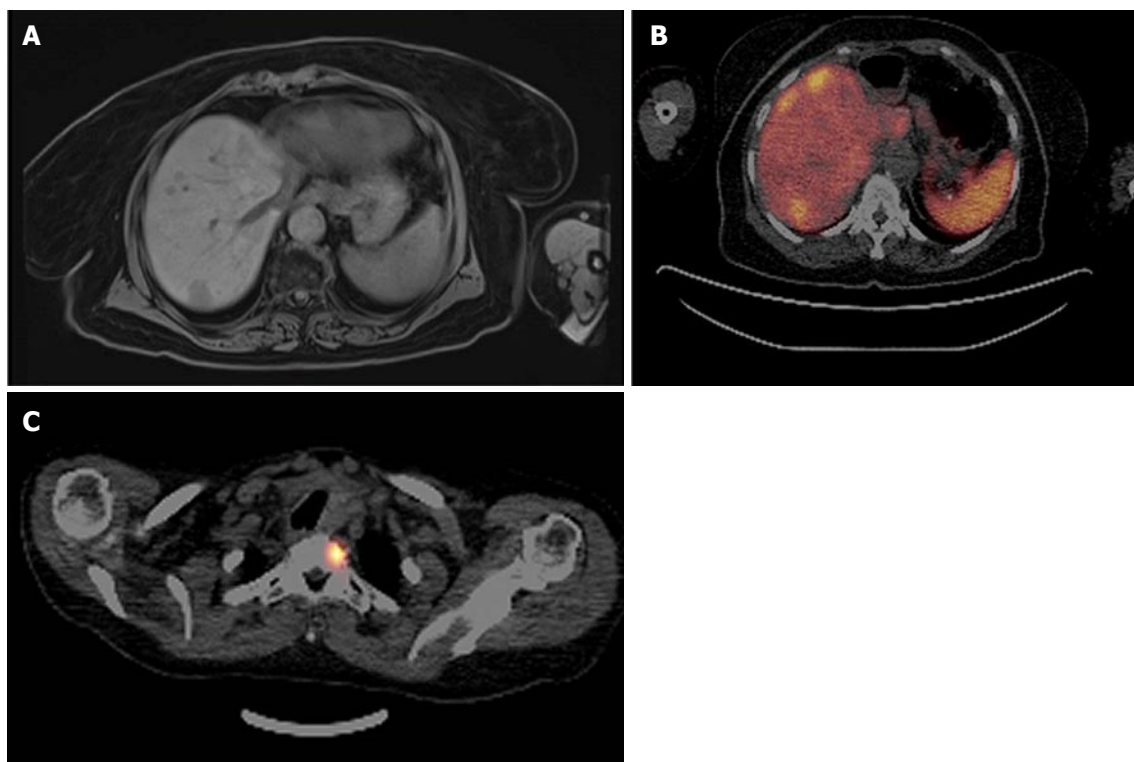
Multimodality imaging in a patient with neuroendocrine liver metastases considered for transplantation. A: Magnetic resonance imaging of the liver in a patient with hepatic metastases from a small bowel neuroendocrine tumour. This patient underwent resection of the primary tumour, and then a left hepatectomy. Following post-hepatectomy lanreotide, peptide receptor radiotherapy and also selective internal radiotherapy for recurrent hepatic metastases, this patient was considered for orthotopic liver transplantation. There was no extra-hepatic disease on conventional cross-sectional imaging. B: ^{68}Ga -DOTATATE PET/CT in the same patient. Multiple foci of increased avidity are demonstrated within the liver that were not appreciated on magnetic resonance imaging. C: Radiotracer uptake corresponding to one of multiple bone metastases. According to standard criteria, these would exclude this patient from orthotopic liver transplantation.
